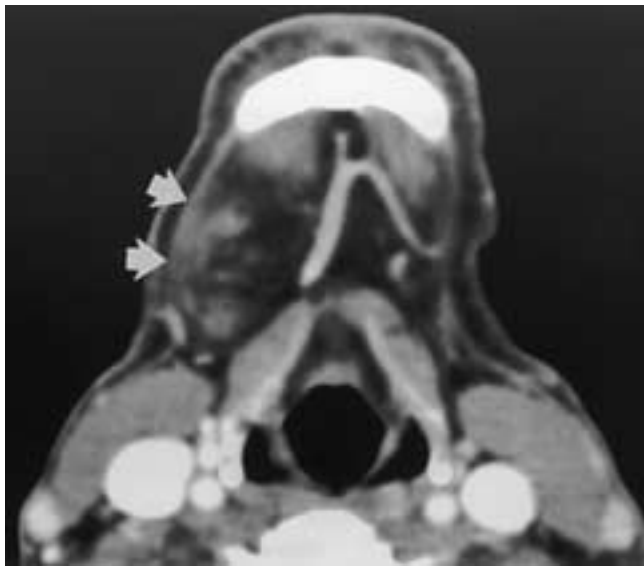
Liposarcoma in the right submandibular space. Axial contrast-enhanced CT scan reveals a poorly defined tumor in the right submandibular space fat. Soft-tissue density material as well as dirty-appearing fat is present in this lesion, which bulges the right platysma muscle laterally (*arrows*).
